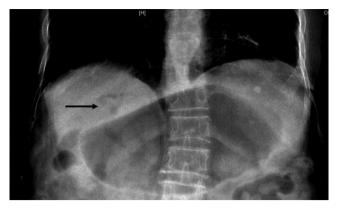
Chest x-ray showing the gastric distension and pneumobilia (black arrow).
